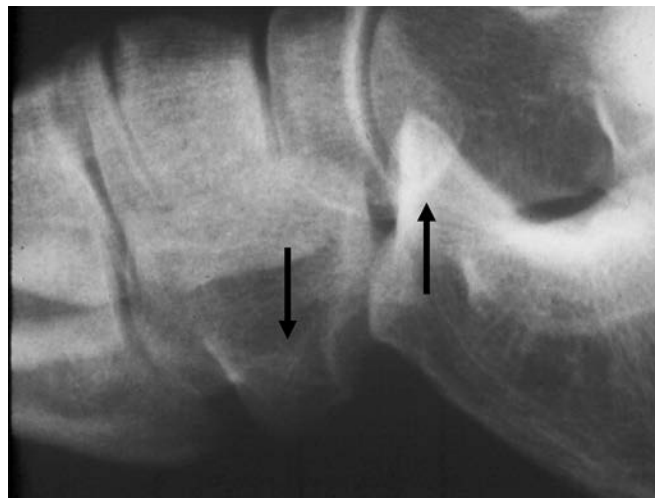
Cuboid Subluxation in Dancers. Radiographic lateral view demonstrating the plantar subluxation of the cuboid at the calcaneocuboid joint.
